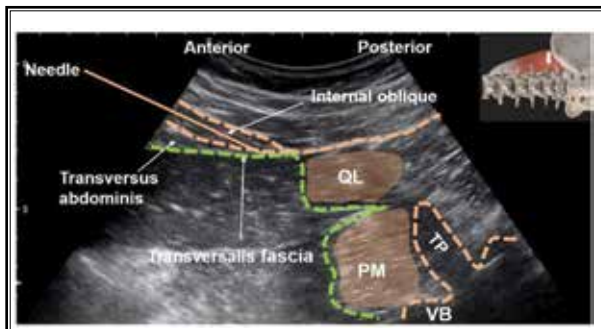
The sonogram of a TFPB. The green line shows that the TF travels on the QL and PM muscles' surface. The orange line shows that the TA and internal oblique gradually taper backward to form a common aponeurosis. The needle is punctured from anterior to posterior until the tip arrives at the deep surface of the TA muscle. The inserted image indicates the probe's position.
